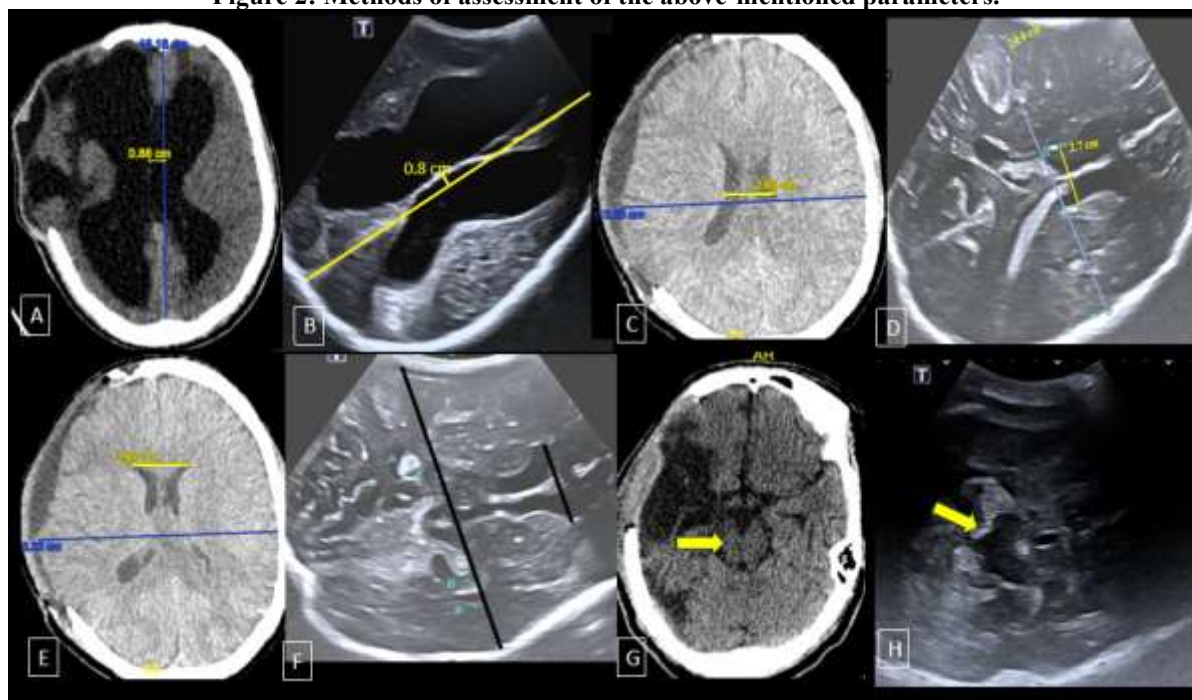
Images A-H are axial non-contrast CT sections of the head in brain window and corresponding axial TCS images.
